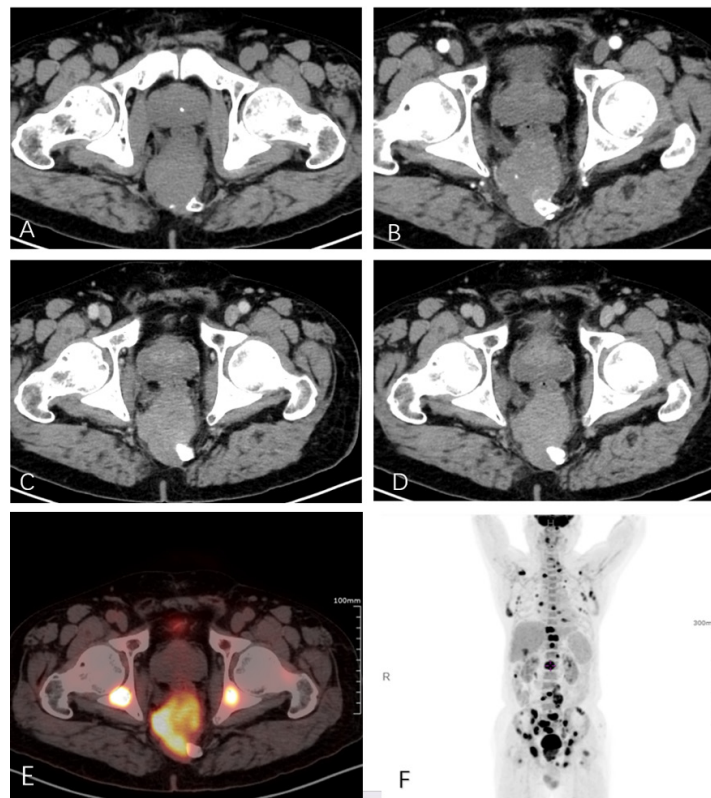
18F-PET/CT image showing a mass located in the presacral region. (A) Axial unenhanced CT image showing an irregular mass invading the posterior wall of the rectum. (B) Axial contrast-enhanced CT image showing enhanced small vessel shadow in the mass (C) Venous phase (D) Delayed phase (E) 18F-FDG metabolism map (F) Maximum intensity projection.
